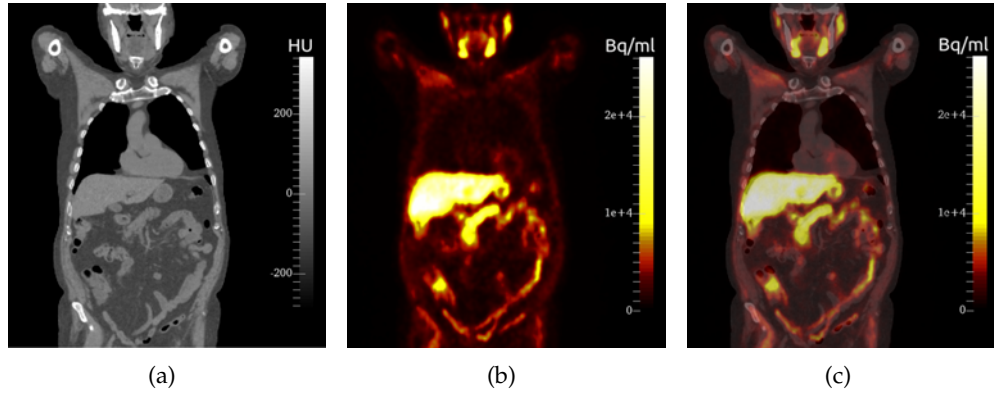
Coronal slices of the resampled CT (a), the native PET (b) and of the fusion of the two (c).
